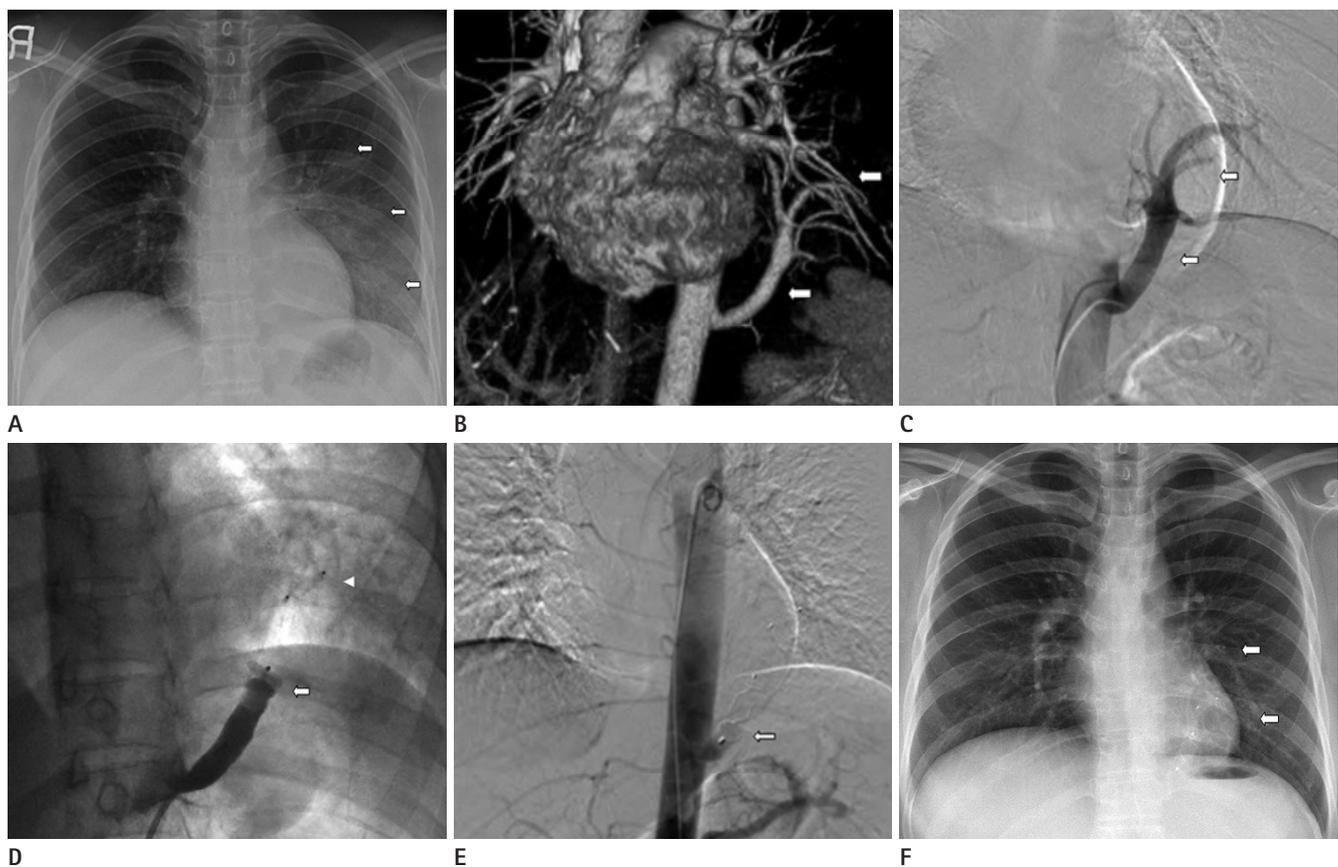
Interventional embolization with type II Amplatzer Vascular Plug for the intralobar pulmonary sequestration in a 30-year-old woman. A. Initial chest X-ray reveals large ill-defined consolidations in the left lower lung (arrows). B. The three-dimensional reconstructed thoracic aortography with volume rendered technique shows a large feeding artery and numerous parenchymal branches of the sequestered lung, which originate from the lower thoracic aorta to the left lower lung field (arrows). C. Selective arteriography of the feeding artery with a 5 F diagnostic catheter shows an 8.5 mm feeding artery (proximal) branching from the lower thoracic aorta to the left lower lung field (arrows) with drainage to the left atrium via the left inferior pulmonary vein. The shape of the branching vessels from the feeding artery has the appearance of a caput medusae with multiple smaller distal branches. D. After infusion of a larger amount of gelatin sponge particles, which had been soaked in 4 g cephtriaxone, to the periphery of the distal branches of the feeding artery and loading of an 8 mm plug into the 5 mm sized distal lumen in the main trunk of the feeding artery (arrowhead), we deployed a 12 mm type II Amplatzer Vascular Plug into the 8 mm sized proximal lumen in the main trunk of the feeding artery (arrow). E. Final thoracic aortography shows the totally occluded main feeding artery and the Vascular Plug placed within the proximal lumen of the feeding artery (arrow). F. The 1-year follow-up chest PA shows the disappearance of the sequestered lung lesion in the left lower lung (arrows).
